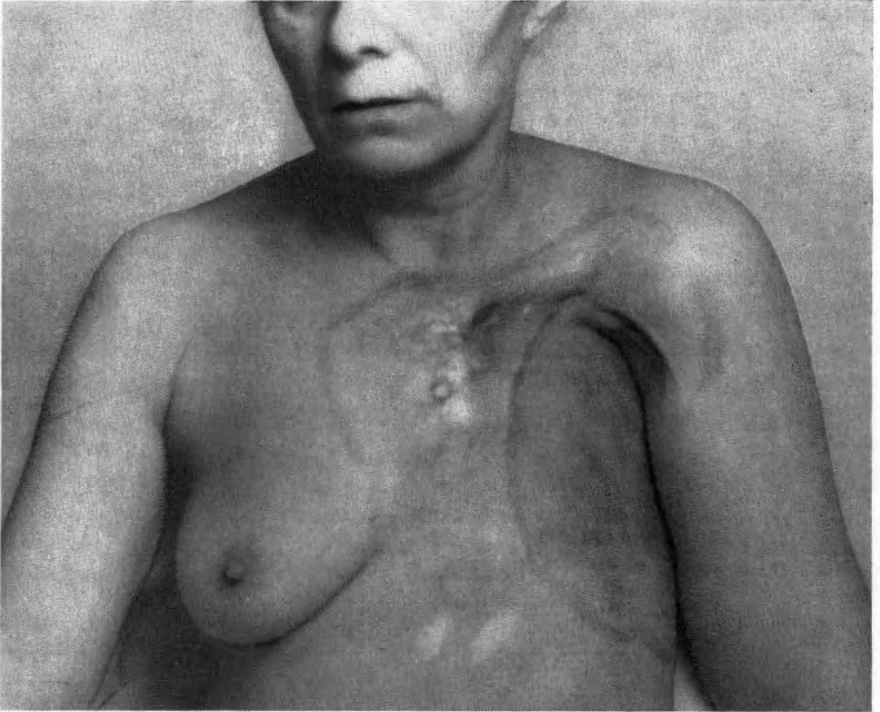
Irradiation for post-operative recurrence. A standard cycle of post-operative irradiation has been given following recurrence in the parasternal region.
